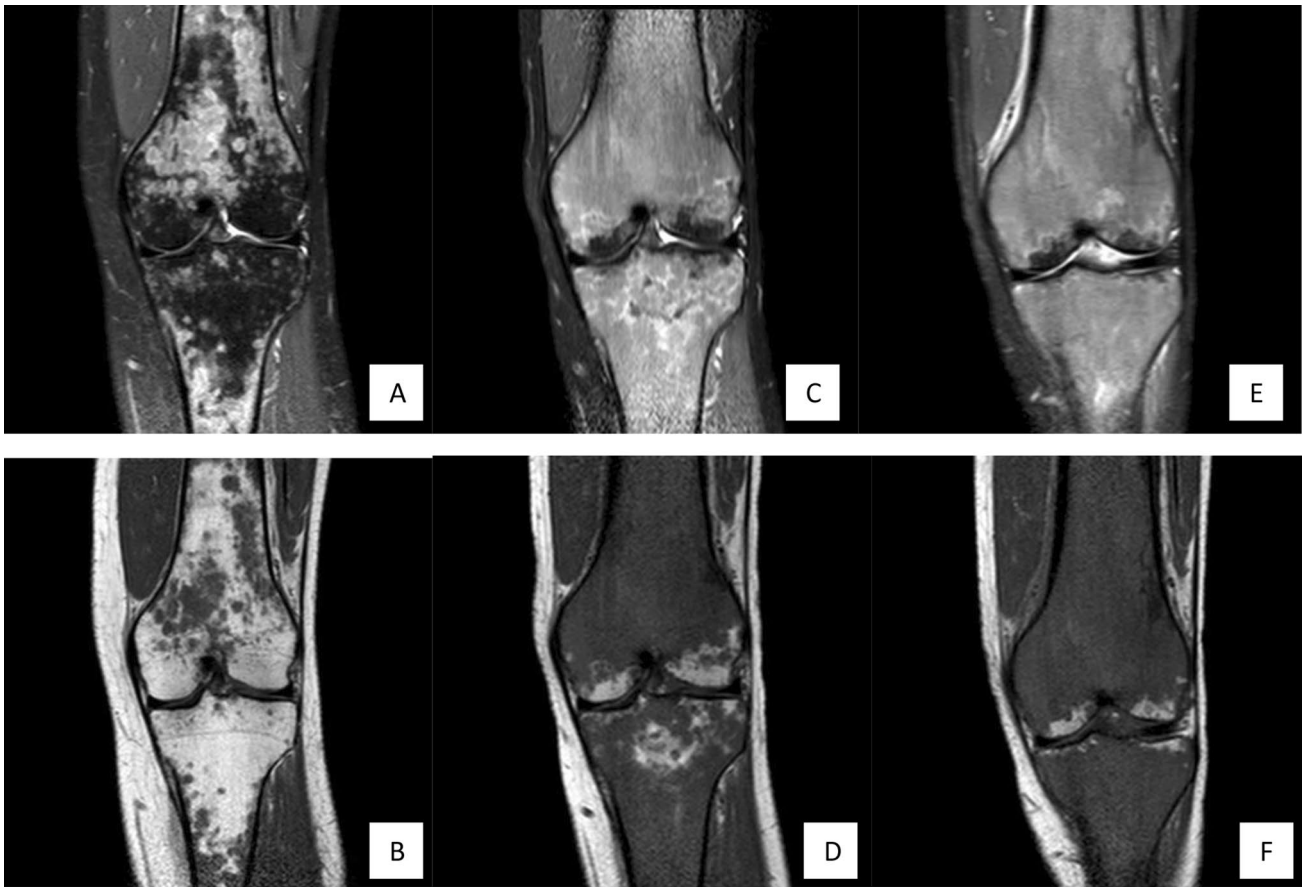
MRI of the left knee showing multiple focal bone marrow lesions which hyperintense on PD FS (a) hypointense on T1WI (b) and no bones cortical thickness before treatment (a, b); diffuse bone marrow lesions, femur cortical thickness and osteonecrosis
